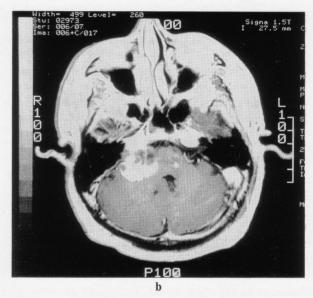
(a: sagittal, b: transaxial) MRI reveals a round mass enhanced by Gd-DTPA at the cerebello-pontine angle with a compression to the pons and the cerebellum. The compression suggests to cause the hypoperfusion, but does not extend up to the half side of the brainstem and cerebellum.
